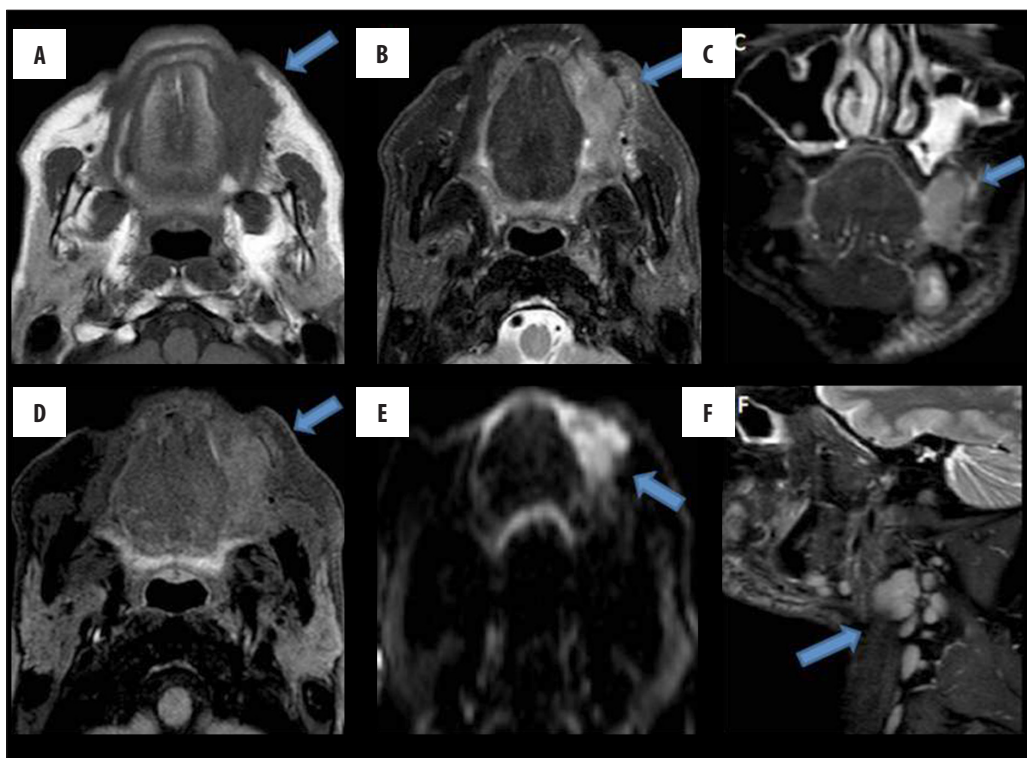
Shows a mass lesion with ill-defined soft tissue signal intensity, involving the buccal space on the left side, appearing isointense on T1W (A), hyperintense on T2W (B) and STIR coronal images (C), showing mild enhancement (D). Restriction on DWI (E). Laterally, reaching up to subcutaneous tissues. Medially, indenting the left lateral margin of the tongue with well-defined fat planes in between. (F) shows enlarged lymph nodes at levels 1b, II, III on the left side.
